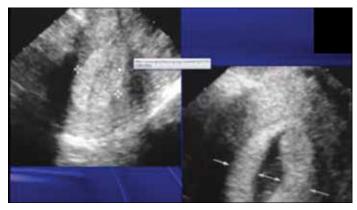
Endometrial hyperplasia before and after saline infusion sonography
